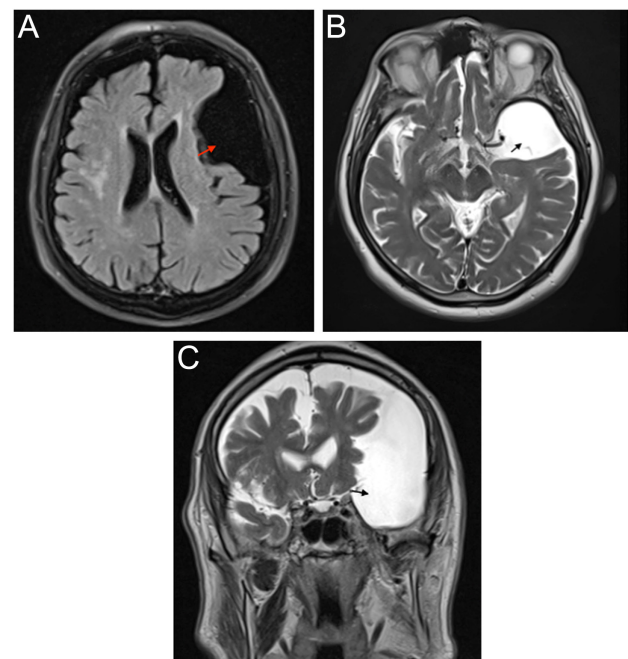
Magnetic resonance images of the patient a year ago: (A) Axial Fluid attenuated inversion recovery (FLAIR): left-sided intracranial Galassi type 3 arachnoid cyst (red arrow). (B) Axial T2-weighted magnetic resonance imaging: left-sided intracranial Galassi type 3 arachnoid cyst (black arrow). (C) T2-weighted coronal magnetic resonance imaging: left-sided intracranial Galassi type 3 arachnoid cyst (black arrow), which displaces temporal lobes significantly and parietal and frontal lobes mildly.
